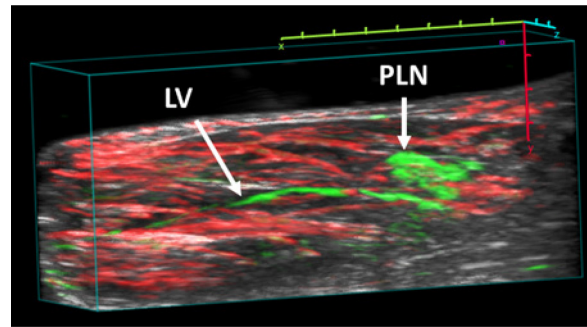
Three-dimensional multispectral photoacoustic image demixed for ICG. The gray, red, and green colormaps represent the ultrasound signal, blood, and relative ICG concentration, respectively. The ICG is isolated to the lymphatic vessel (LV) and the popliteal lymph node (PLN). Scalebar represents 1 mm per tick.
